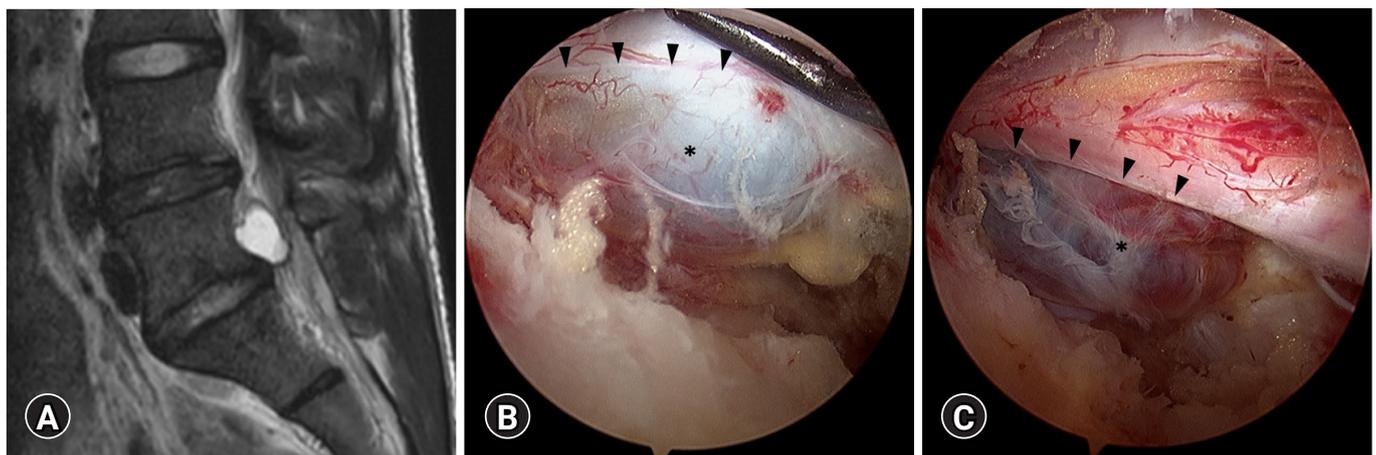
(A) Pre-operative MRI: the broad base cystic mass with posterior displacement of the S1 traversing nerve root. (B) The intra-operative photo: severe adhesion (black arrowheads) with a vague plane between the cyst (asterisk) and the dura. (C) The dark blue hemorrhagic cyst (asterisk) was isolated after meticulous dissection to release the adhesion from the dura and the S1 nerve root.
